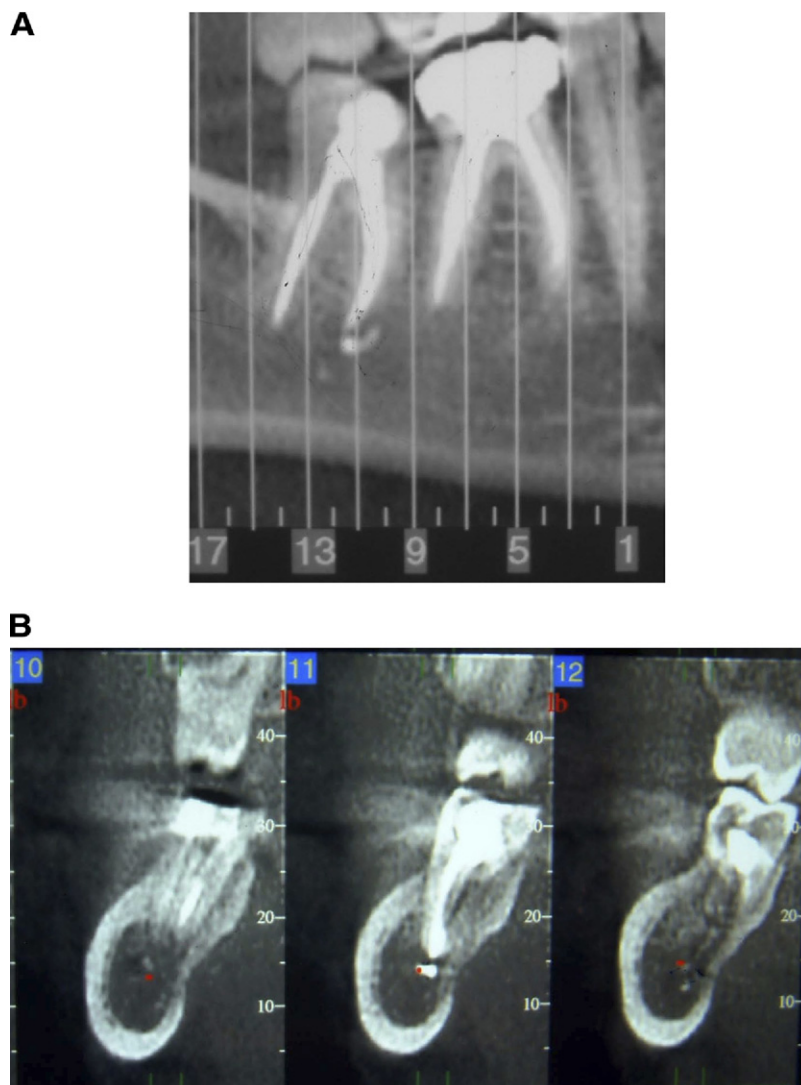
A dental CT scan of a 40-year-old female patient, demonstrating a gross overfill of root canal sealing material (AH-26) following root canal treatment of the second mandibular molar. The overfill is located at the mesial root and vertical lines are superimposed reflecting the tomographical slices along the perpendicular plane (A). Details of slices 10 to 12 disclose extruded root canal sealing material into the inferior alveolar canal (B). The patient has permanent paresthesia.
